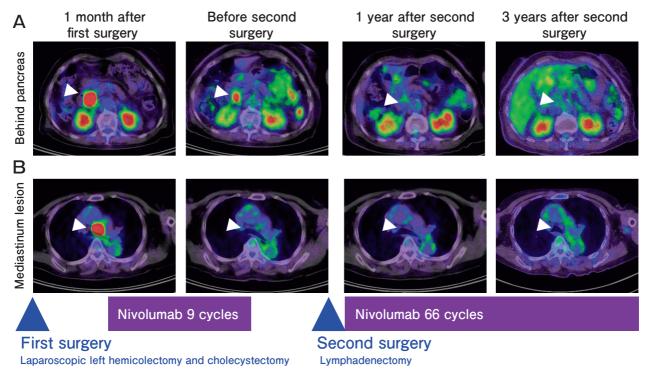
PET-CT shows the course of the metastatic lymph nodes during the nivolumab treatment. A, PET-CT showing the metastatic lymph node behind the pancreas head (*arrowhead*); B, PET-CT showing the metastatic lymph node at the mediastinum lesion (*arrowhead*).
